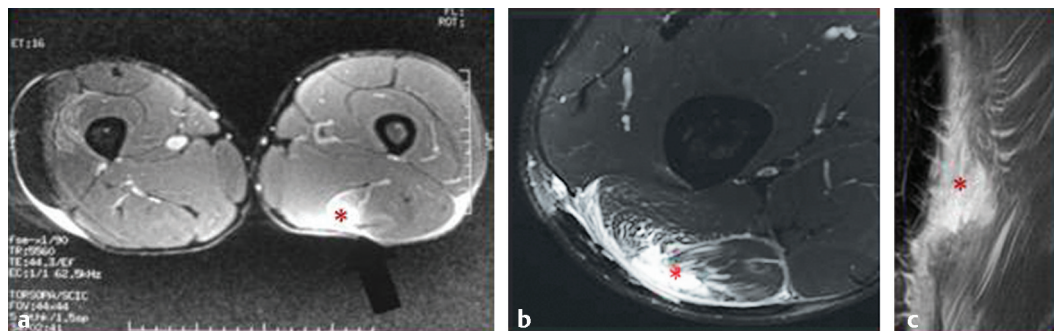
(a) It is not possible to judge from this low-quality image if an edema or hematoma (* seen as a white spot/bright signal on the MRI) is obscuring muscle tissue that may have been structurally damaged. (b,c) High-resolution images (3T; surface coil; limited field of view) demonstrate more clearly the actual defect in the muscle structure (*). The torn muscle tissue can be determined more precisely within the bright signal. However, even though these images are of high quality, it is difficult to measure the actual defect size in the muscle tissue.
